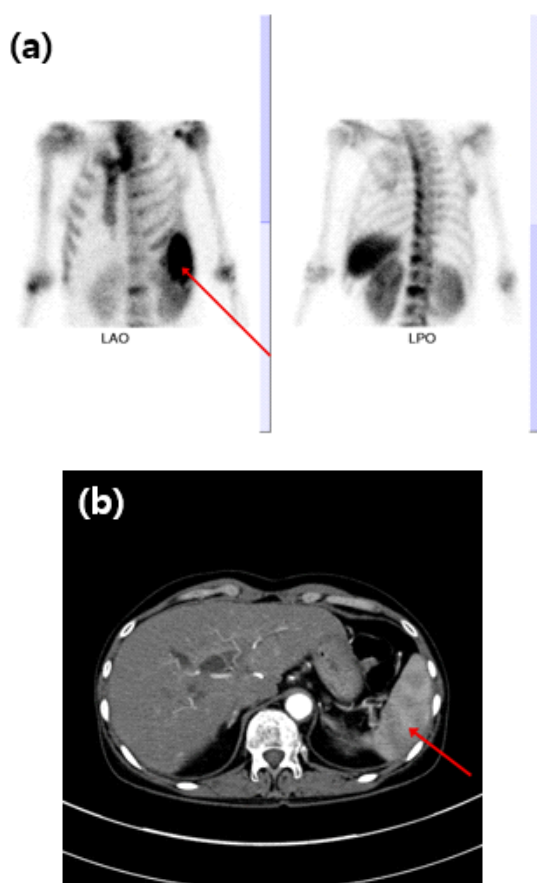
Diffuse splenic uptake Tc-99m DPD bone scan imaging (a) and the contrast enhanced CT imaging (b) findings were consistent with splenic infarction. Correlative contrast enhanced computed tomography images are located the bone scan images with spleen infarction lesions marked by an arrow.
